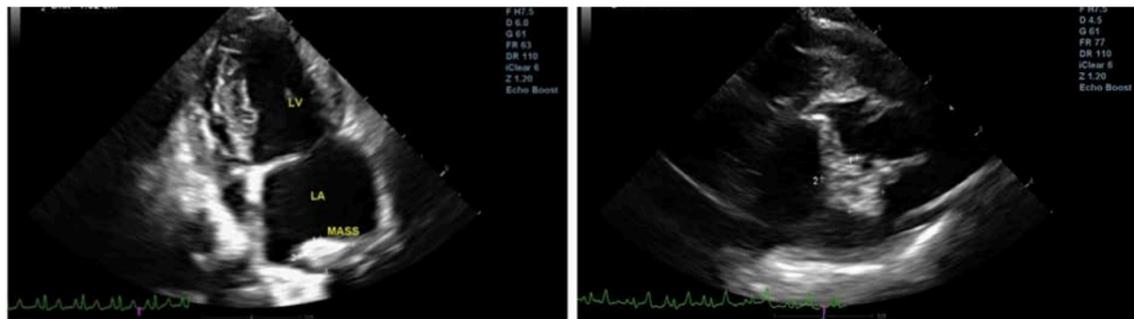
Results of echocardiogram examination after the treatment showed cardiac mass in the left atrium at the heart base which led to diagnosis of heart base tumor
